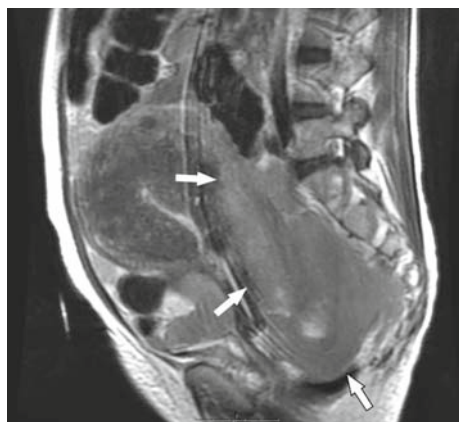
EBV-positive sporadic Burkitt lymphoma in a 52-year-old woman. She was treated with chemotherapy, which resulted in a complete response. Sagittal T2-weighted MR image shows a soft tissue mass of heterogeneous intensity filling the pouch of Douglas (arrows). The border between the mass and uterus, which is enlarged with adenomyosis, is ill-defined
